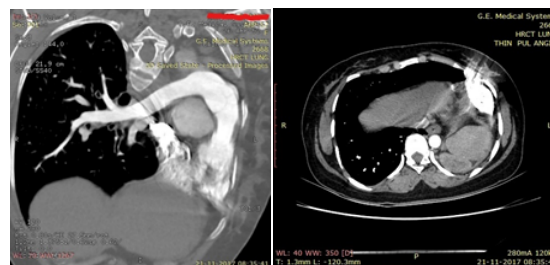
CT image showing retrosternal and prevertebral herniation of right lung
